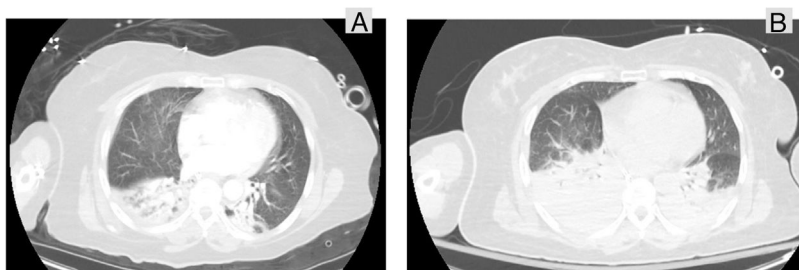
A) Computed tomography (CT) scan upon admission to the Intensive Care Unit; B) CT scan 16 h after admission, coinciding with severe hypoxemia.
